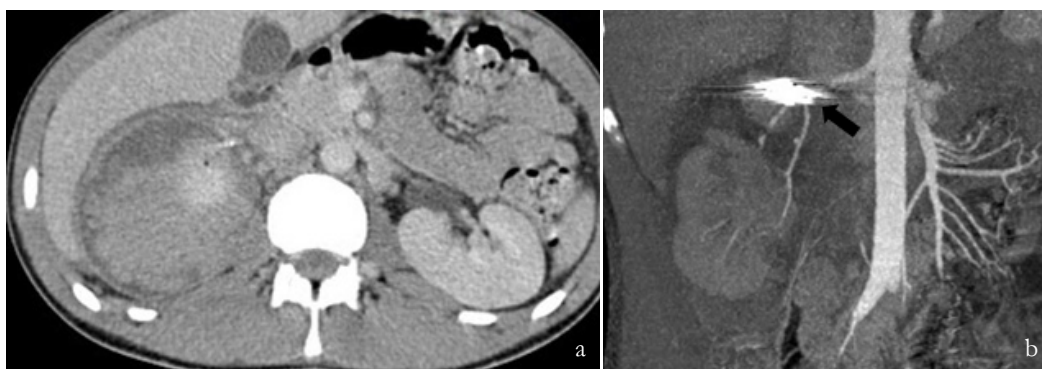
Contrast-enhanced axial (a) and coronal (b) CT images confirming the exclusion of the PA with microcoils (arrow) and preserved vascular flow to the remaining segmental arteries.
